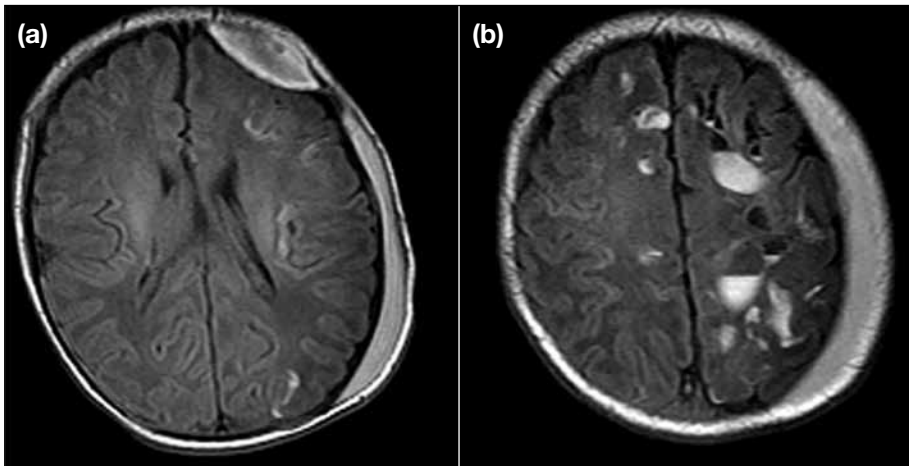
Spin-echo T1-weighted magnetic resonance imaging showing (a) left epidural haematoma, and (b) parenchymal haemorrhage.
